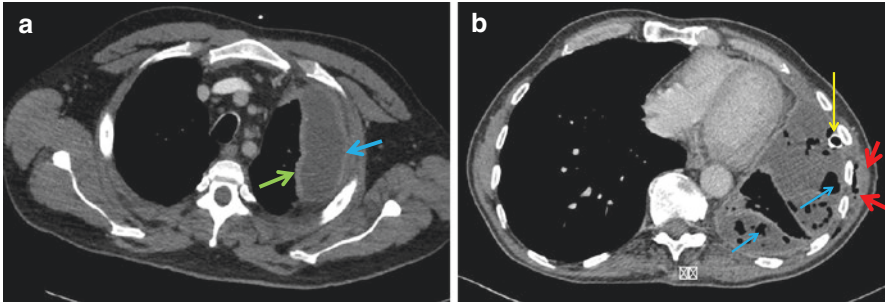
(a) Axial contrast enhanced CT slice demonstrating a left sided pleural collection / TB empyema, with an apparent split pleura sign demonstrating smooth enhancement of the visceral pleura (green arrow) abutting the lung and the parietal pleura (blue arrow) abutting the chest wall. (b) Axial contrast enhanced CT slice with a complex loculated left sided pleural collection with smooth pleural enhancement and multiple gas locules (blue arrows). The pleural collection communicates with fluid and gas pockets in a chest wall collection superficial to the ribcage. This constitutes an empyema necessitans. There is a large bore left sided chest drain in situ (yellow arrow)
